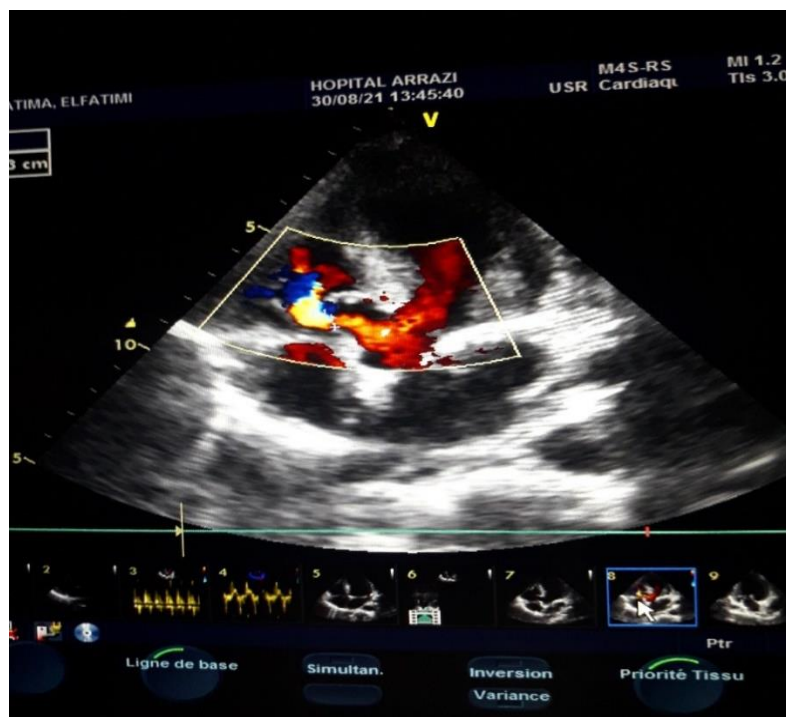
4-chamber view showing a left-right interventricular shunt on color Doppler
